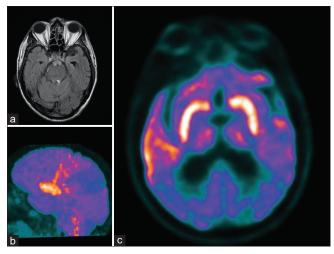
(a) FLAIR axial section MRI showing no limbic hyperintensities. (b and c) FDG-PET sagittal and axial sections showing hypermetabolism in bilateral basal ganglia
